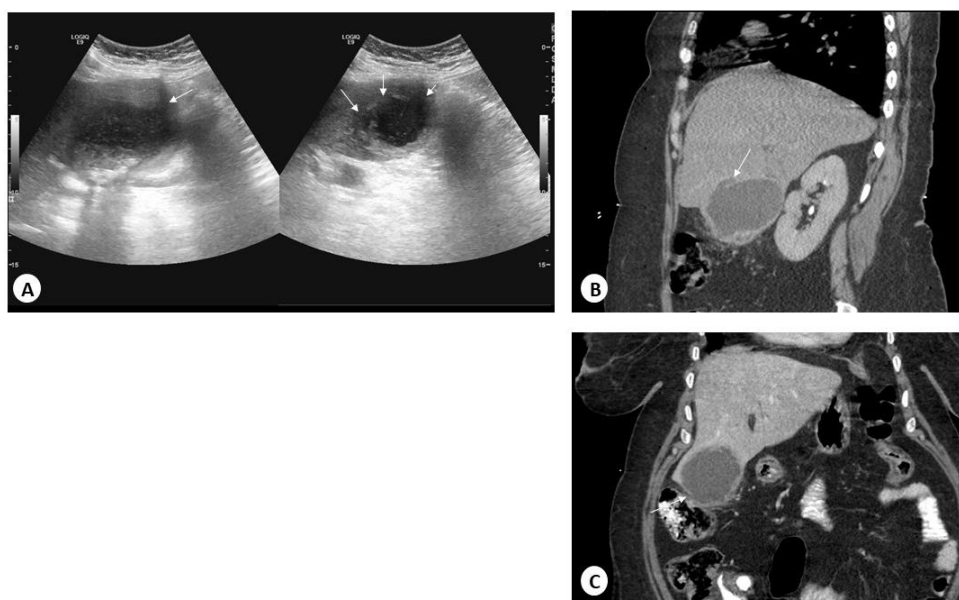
A. transabdominal US showing distended and thick-walled gallbladder with multiple wall defect (arrows) and minimal pericholecystic fluid. B(Sagittal) & C(Coronal) contrast-enhanced CT showing the defects (arrows) in the gallbladder wall and minimal pericholecystic fluid.
